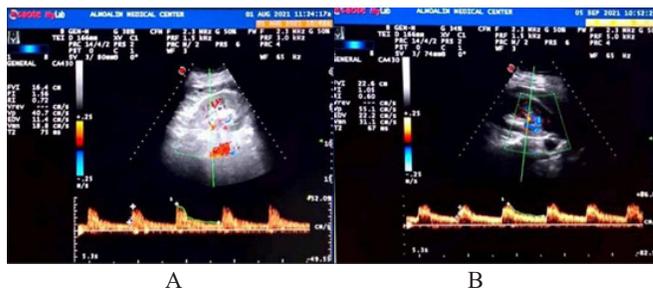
Doppler ultrasound showing high (A) and normal (B) Resistive Index (RI) and Pulsatility Index (PI)
